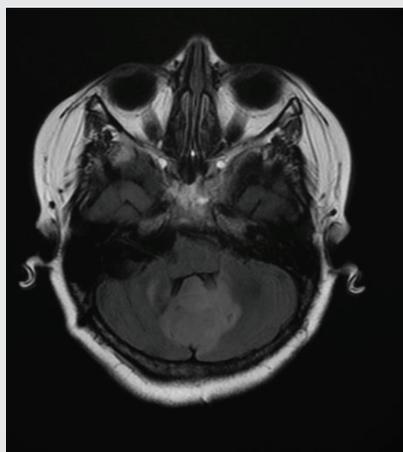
Axial T2 FLAIR image demonstrates a T2 hyperintense posterior fossa mass involving the vermis and medial aspect of the bilateral cerebellar hemispheres. There is mass effect on the fourth ventricle.
